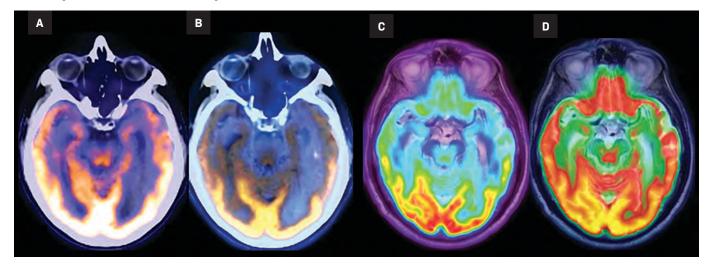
Positive amyloid PET study demonstrating diffuse binding of the amyloid tracer to the Aβ plaque in the cortex. Left (A,B) Amyloid PET-CT fusion images at the level of the temporal lobes; (C,D) Amyloid PET-MR fusion images at the level of the frontal and parietal lobes (with axial T2 used for MR fusion).
